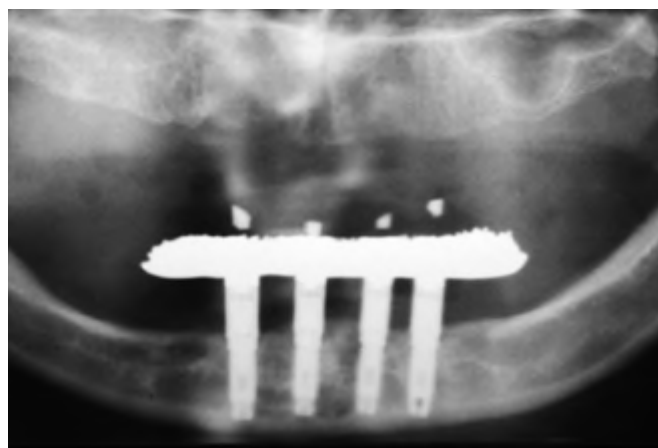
Panoramic radiograph approximately 1 year post occlusal loading of the mandibular implants. This radiograph demonstrated minimal bone loss around the endosseous implants.
